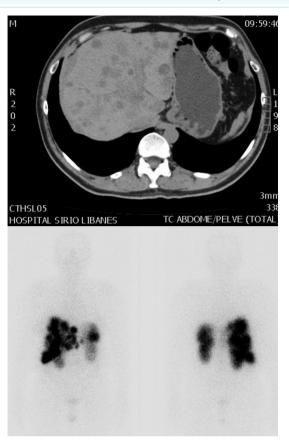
A CT scan showed multiple hepatic metastases, deemed unresectable by the surgeon. A new Octreoscan showed significant uptake in the liver nodules: no extrahepatic disease was detected.
